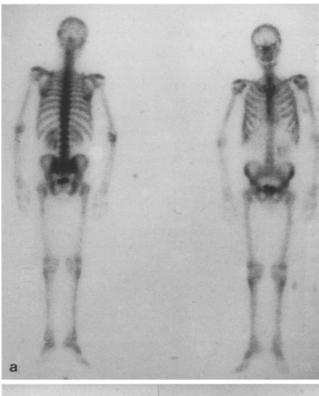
BS. a Whole-body scan showing skull and rib metastases. b View centered on skull (in the same patient) exhibiting the metastasis (MRI was negative in this patient)
